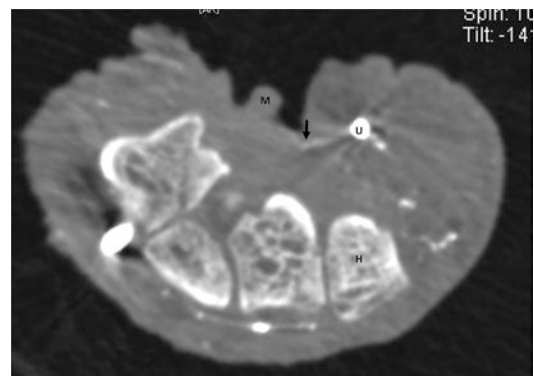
Intraoperative CT angiogram at the level of the hamate after performing external neurolysis of the median nerve. Another direct branch of the ulnar artery to the flexor synovium is identified. *H* hamate, *M* median nerve, *U* ulnar artery, *Arrow* the direct branch of the ulnar artery to the flexor synovium
